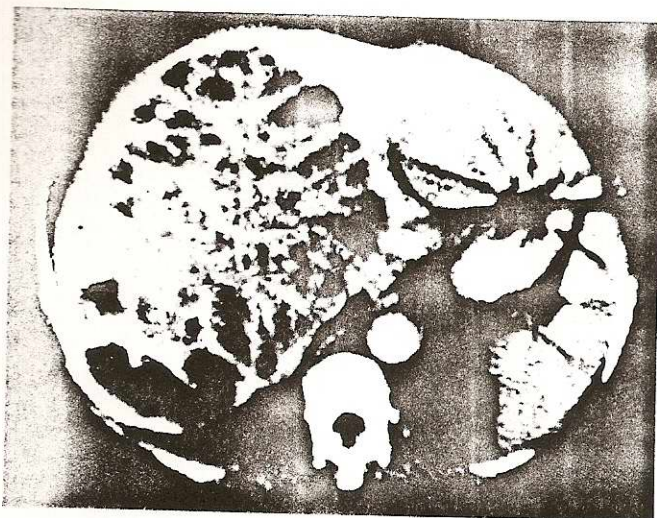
CT scan disclosing a multilocular pyogenic liver abscess.
